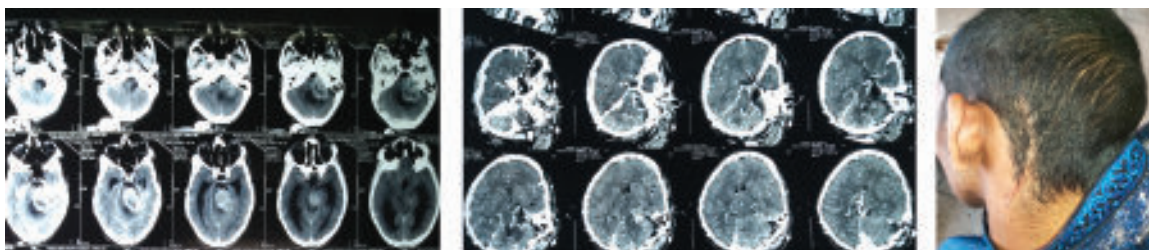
Gross Total removal of Aquastic Schwannoma (pre op- post op CT and patient)
